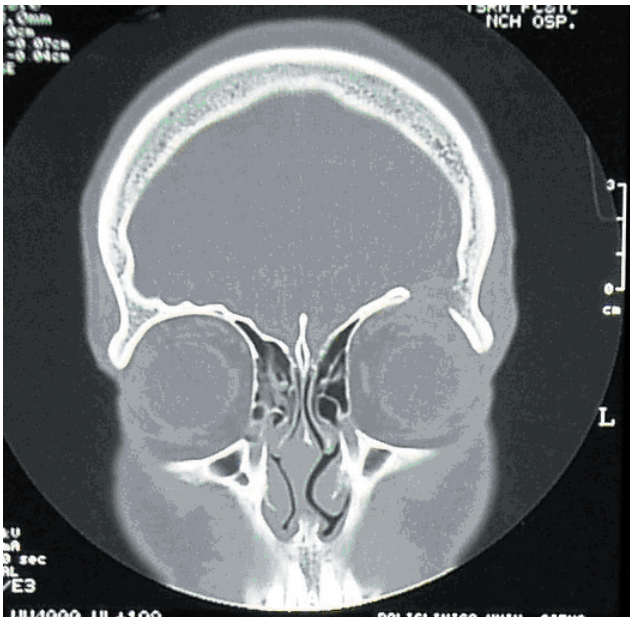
Coronal CT scan shows the osteolytic area.
